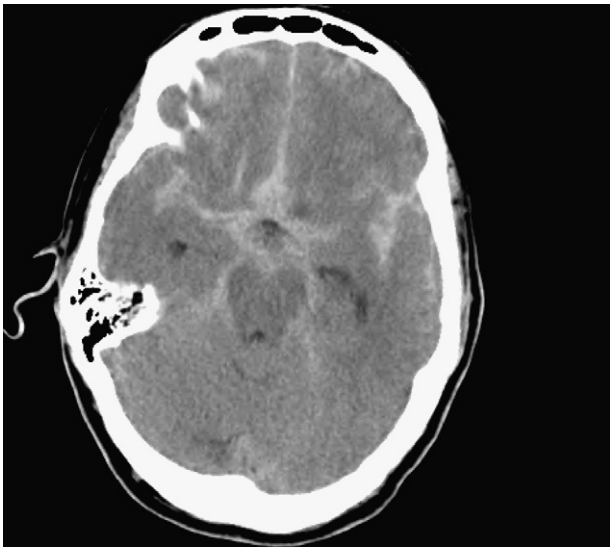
Initial non-contrast CT taken shortly after the patient presented to the emergency room reveals diffuse cysternal subarachnoid hemorrhage.
